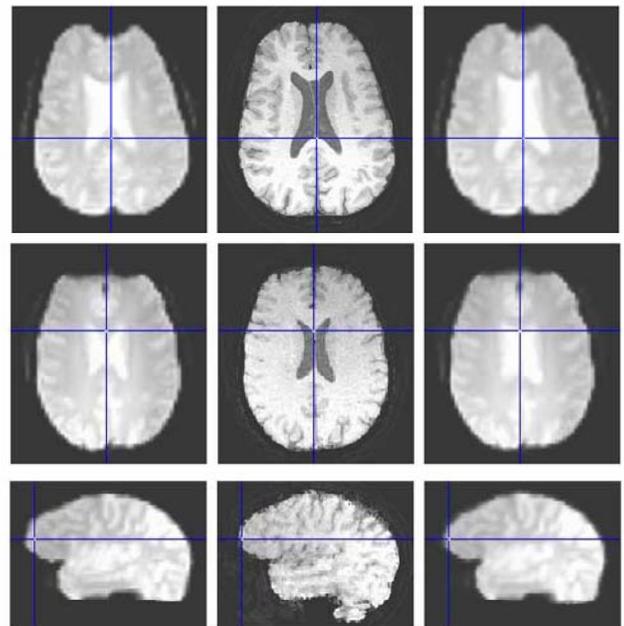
left to right: EPI (after rigid registration), MRI anatomical image, and EPI (after non-rigid registration) of three different datasets
